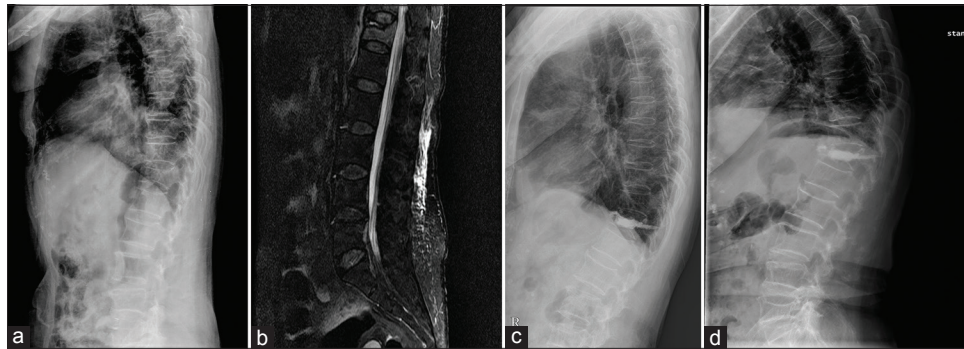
AT12 osteoporotic vertebral compression fracture in a patient with rheumatoid arthritis (case number 3). (a) Preoperative radiograph. (b) Preoperative magnetic resonance image. (c) Postoperative radiograph showing cement filling without leakage. (d) Recollapse after 11 postoperative months
